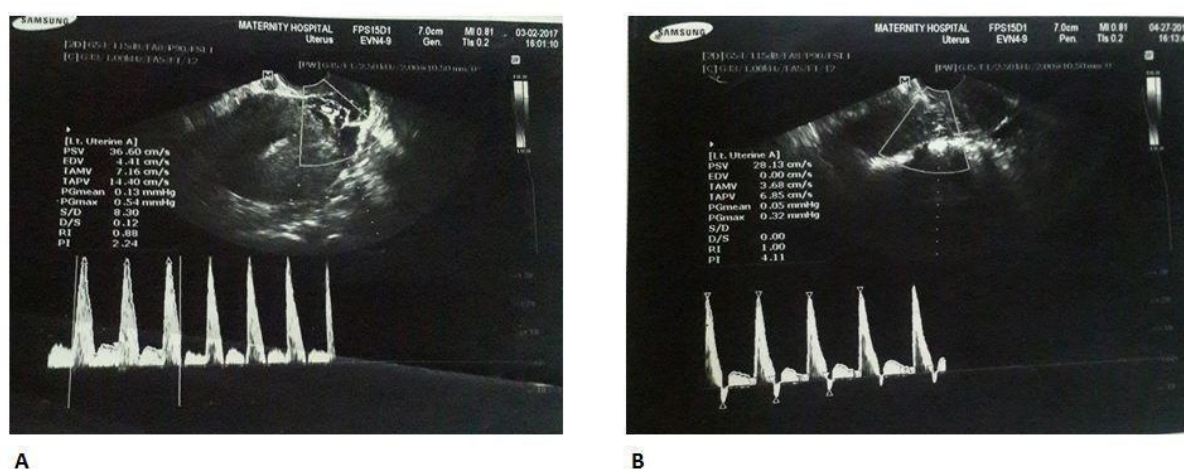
shows the transvaginal color Doppler ultrasound results (pulsatility and resistance indices) for a fertile woman (A) and an unexplained infertile woman (B)
